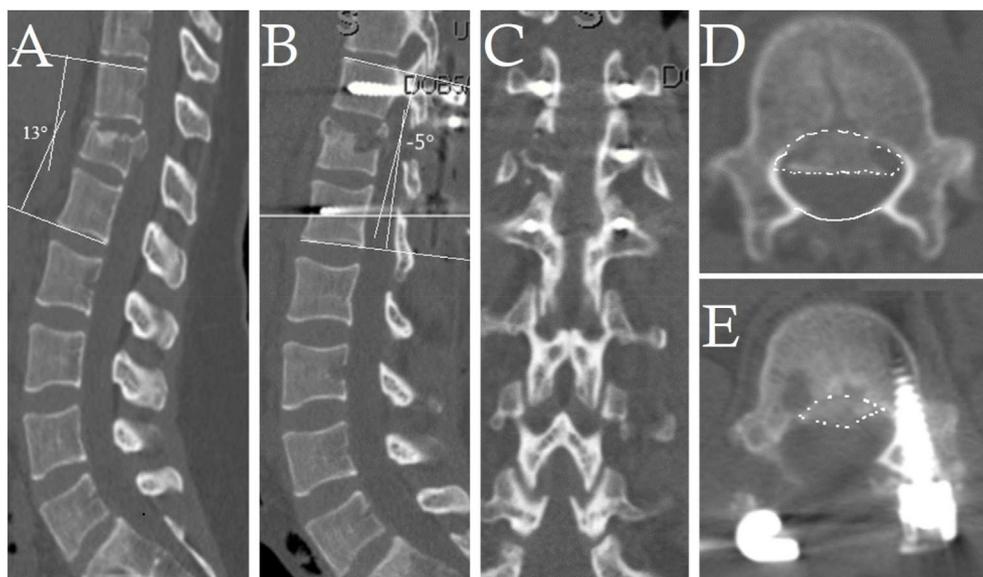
Pre- and postoperative imaging of patient n. 5 (T12 burst fracture): (A) preoperative sagittal CT scan showing T12 burst fracture, kyphosis angle 13°; (B) parasagittal CT scan at the right side showing the pediclectomy and the above (T11), the lower (L1) screws, kyphosis angle (-5°) (lordotic); (C) postoperative coronal CT scan showing the Rt T12 pediclectomy and the short fixation (5 screws); (D) preoperative axial CT scan with 40% canal compromise (retropulsed bone fragment encircled by dotted line); (E) postoperative CT scan showing 15% canal compromise (residual bone fragment encircled by dotted line) and Left T12 screw.
